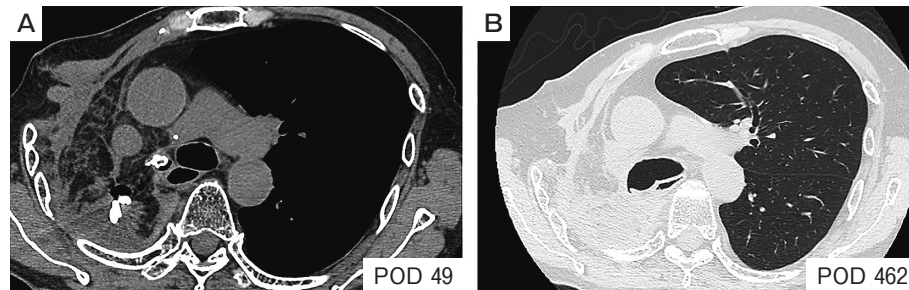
Follow-up computed tomography (CT) scan of the chest on postoperative days (PODs) 49 and 462. (A) n-butyl-2-cyanoacrylate (NBCA) remained in the fistula at the bronchial stump. (B) CT imaging on POD 462 showed no air leakage or empyema, indicating that the bronchopleural fistula had been completely repaired with the NBCA cover.
